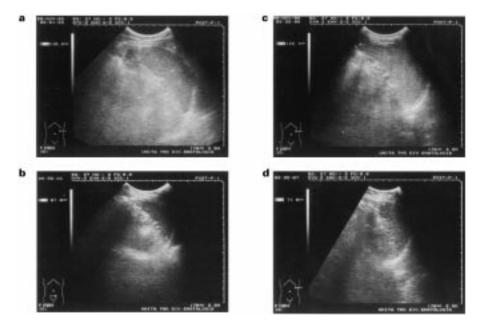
Ultrasound spleen size of two patients with cGVHD (b and d: cases 14 and 18) compared with that of sex- and age-matched transplanted patients without cGVHD (a and c).
